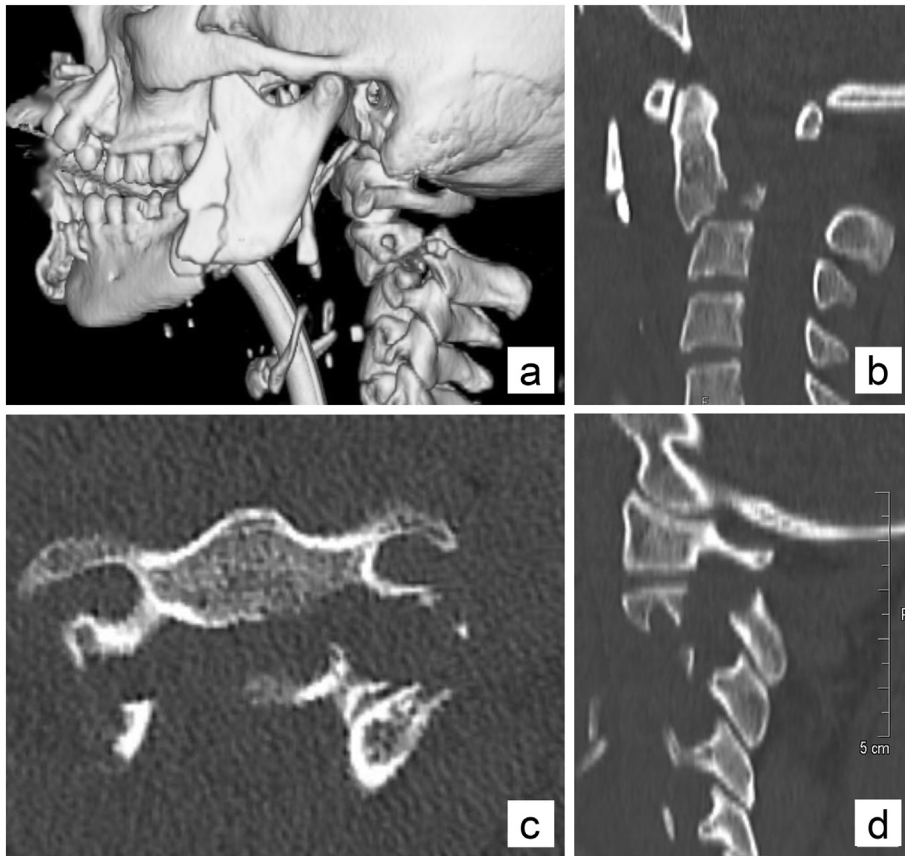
Initial three dimensional (3D) reconstruction of craniofacial and cervical spine CT scan shows the multiple fracture of the maxilla and the mandibula beside the dislocated traumatic spondylolisthesis of the axis (a). Mid-sagittal (b), axial (c), left sagittal (d) CT images present the hangman's fracture.
